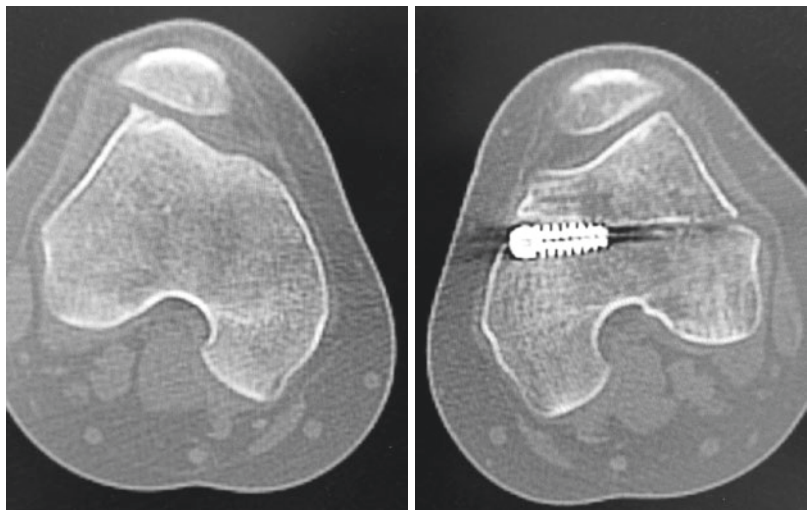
Axial CT scan showing malpositioned femoral tunnel after MPFL reconstruction in the left knee
